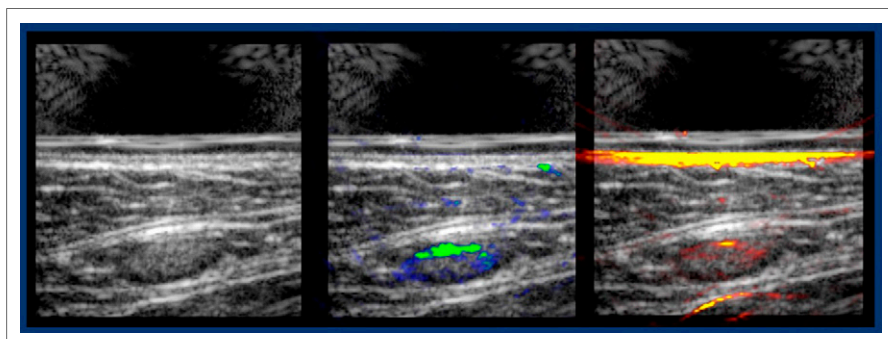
Ultrasound and multi-spectral optoacoustic imaging of a tumor-involved sentinel lymph node in a patient with melanoma. Left: B-mode ultrasound image of a lymph node. Middle: ICG signal superimposed on the ultrasound image, Right: melanin signal superimposed on the ultrasound image.
